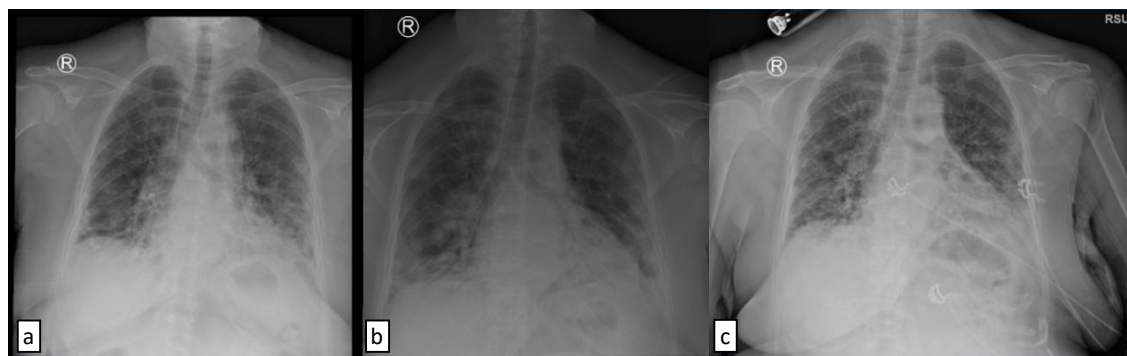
Serial Chest X-ray on: (a) Day 6; (b) Day 16; and (c) Day 26 of Hospitalization of Patient 1.
